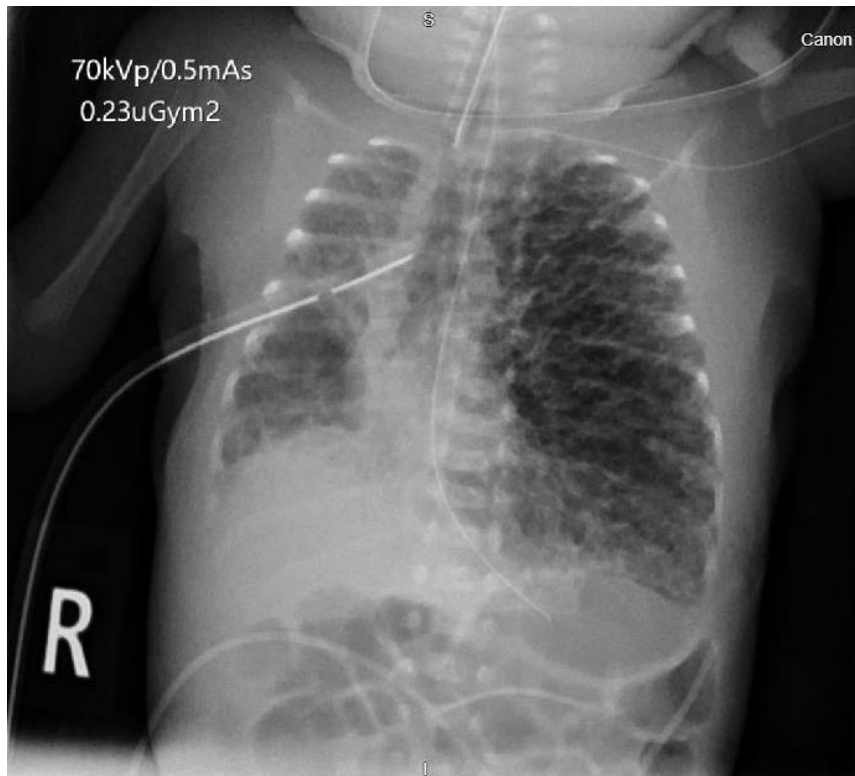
CXR performed earlier the same day as echocardiogram.
